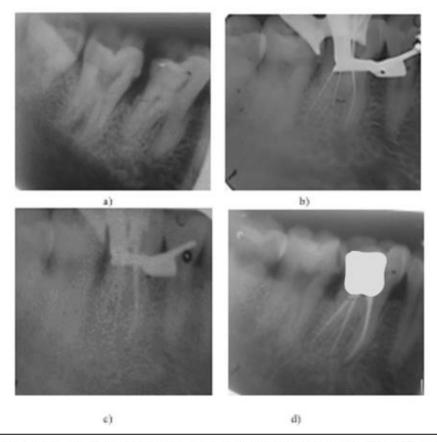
a) Preoperative radiograph irt 36, b) Working length radiograph irt 36, c) Mastercone radiograph irt 36, d) Obturation radiograph irt 36
